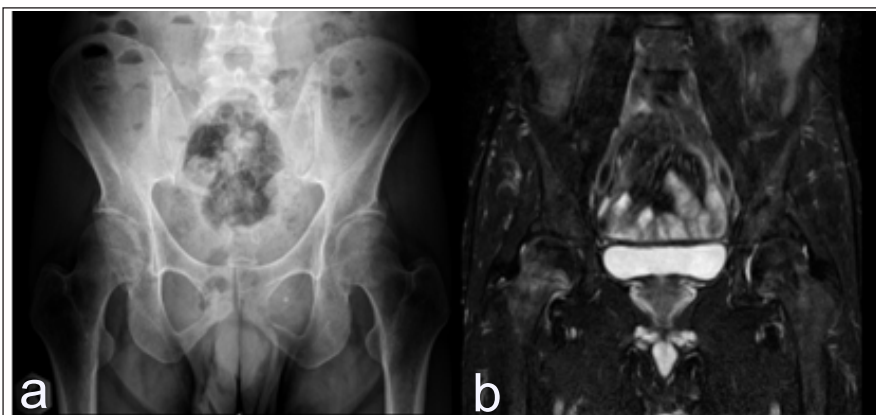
a) Plain radiograph appear to be normal. b) Coronal T1 sequence on MRI showed a fracture line and marked bone edema at the neck of femur.
